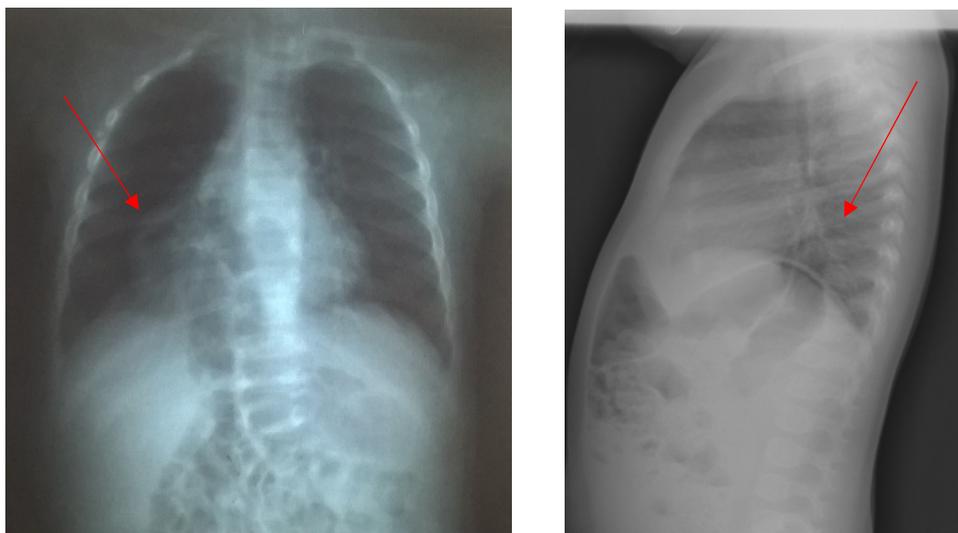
X-ray of the chest with colon loop in the right hemithorax.
